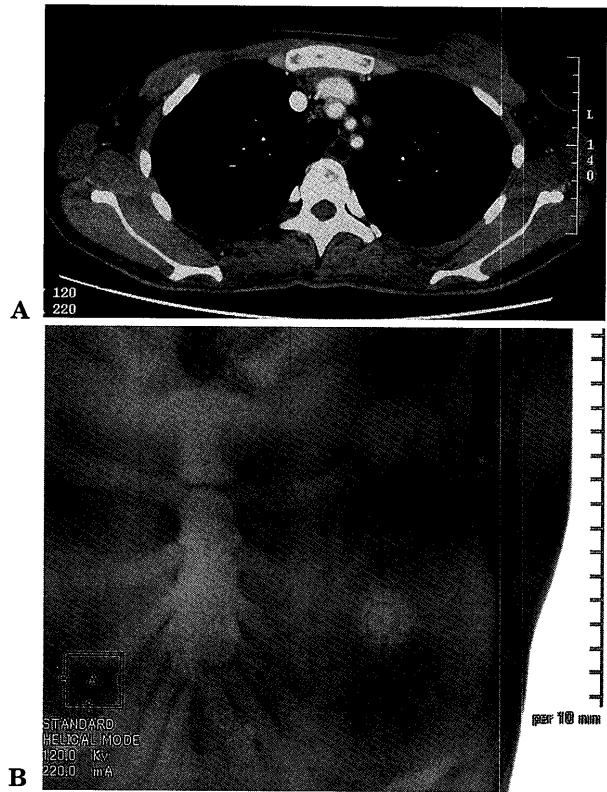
A: CT showed the same finding as ultrasonography.
